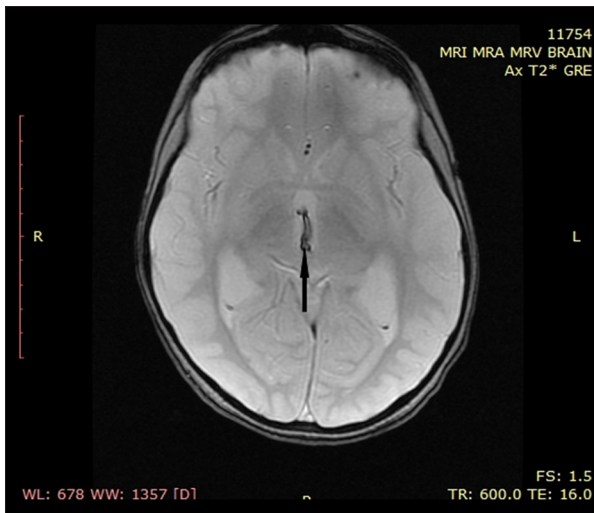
Axial MRI scan, axial T2* GRE, revealing hemosiderin deposition within the third magnetic resonance imaging ventricle. MRI – magnetic resonance imaging; GRE – gradient echo.
